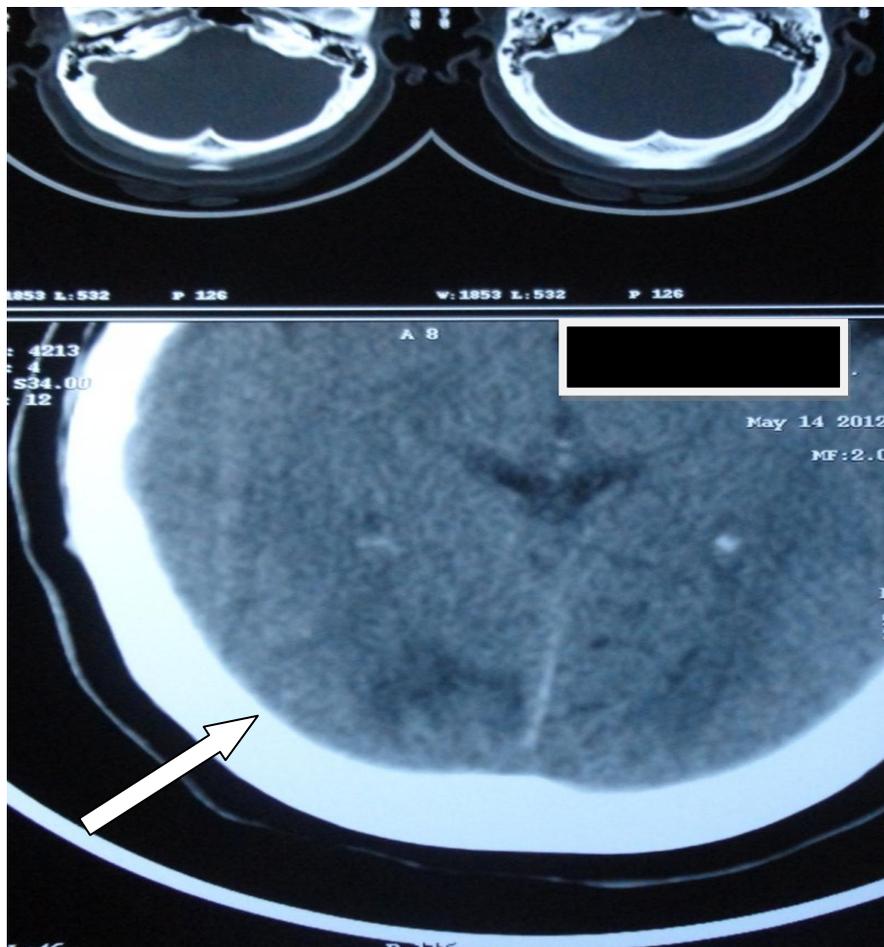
CT sections with arrows showing secondaries in the brain of the patient
